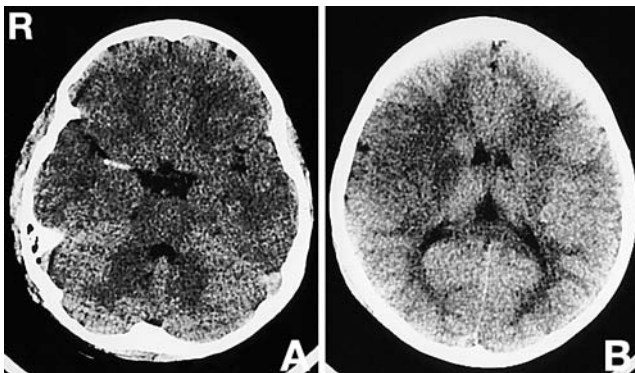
Emergent computed tomography scans just after the development of left hemiparesis showing (A) a clear high-density appearance at the main trunk of the right middle cerebral artery (MCA) or hyperdense MCA sign, and (B) fresh infarction appearing as low-density areas in the territory of the right MCA.
